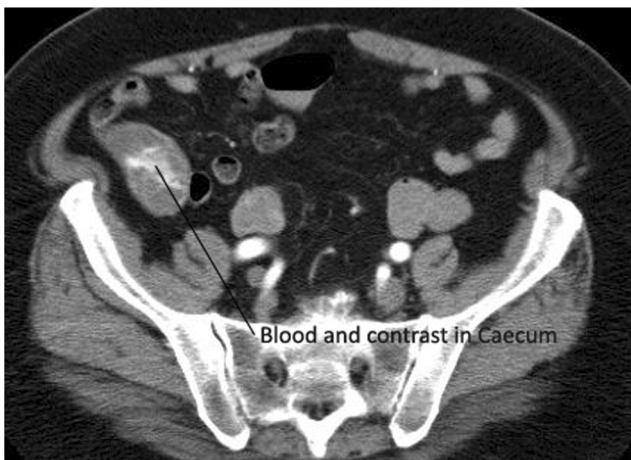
CT angiogram demonstrating blood in the caecum
